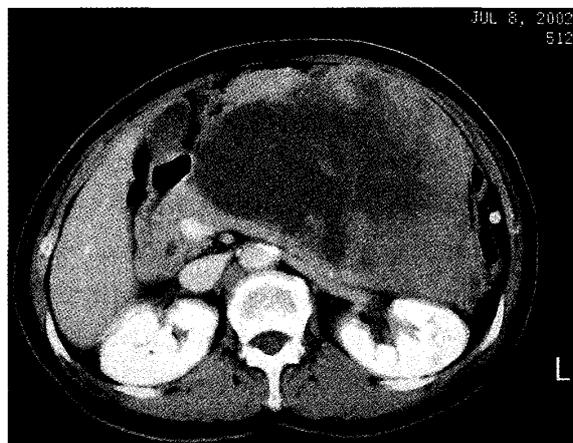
An enhanced CT of the abdomen at the time of admission demonstrated a giant heterogeneous tumor.
